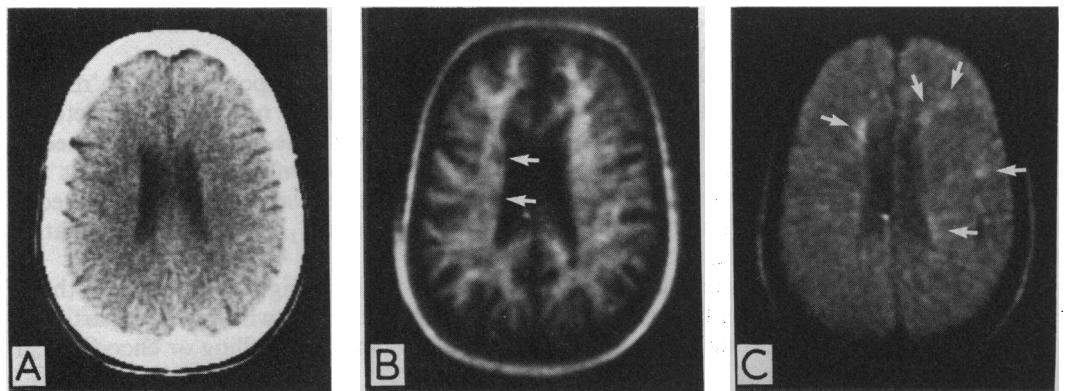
Comparable CT (A), T_1 (B) and T_2 (C) scans of a patient with multiple sclerosis. No lesions are visible on the CT scan, but several are seen on the T_1 scan, two of which are arrowed. The T_2 scan shows further lesions
